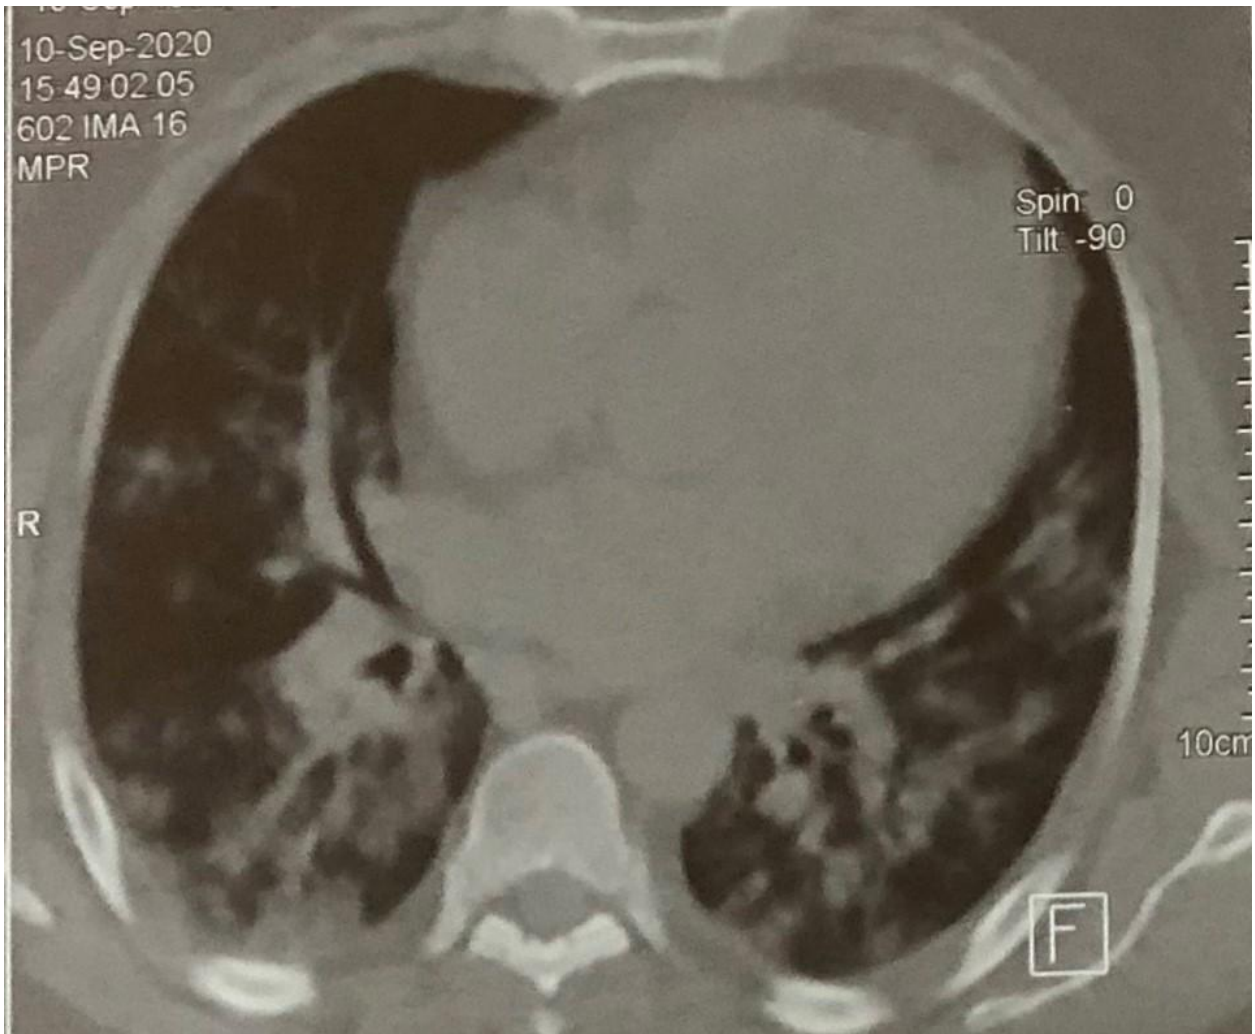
CT Scan of the chest showing peripheral multifocal and bilateral ground glass pattern.
